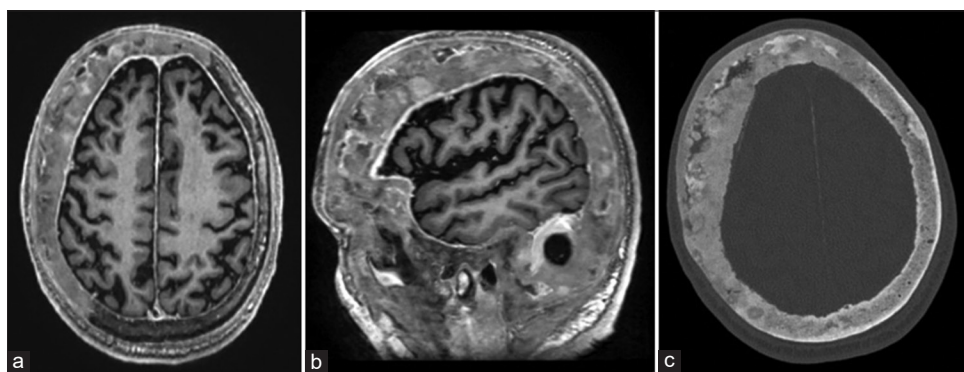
Magnetic resonance imaging T1 with contrast axial (a) and sagittal (b) view showing diffuse calvarial expansion with patchy enhancement in the right frontoparietal, temporal, basilar occipital, basisphenoid, and clival regions. Axial computed tomography bone window (c) showing enlarged diploic space with mixed sclerotic and lytic areas
